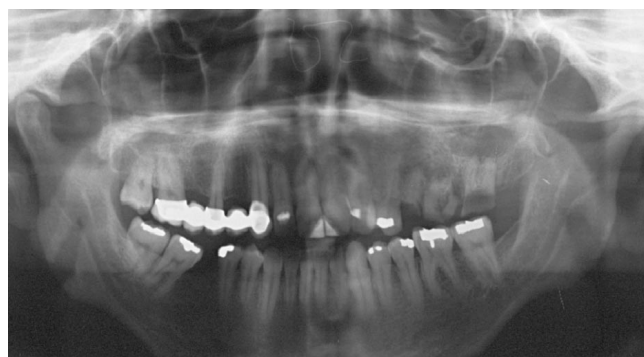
Pretreatment panoramic radiograph of patient 2.
